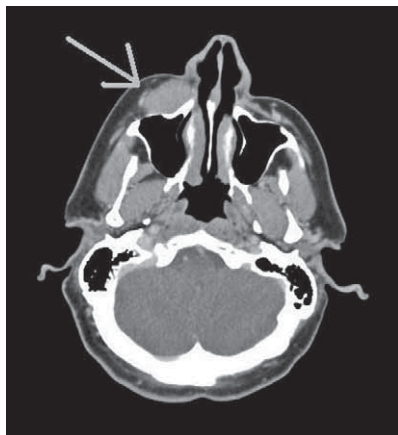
CT scan, axial view, arrow pointing at infiltrative homogenous mass infraorbitally lying on the anterior wall of the maxilla.
